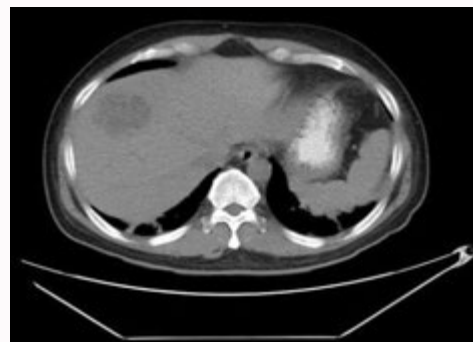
Chest CT scan: bilateral variable size lung nodules, some cavitating, some showing mixed solid and cystic densities and cluster of variable size nodules and fibrotic densities seen in the posterobasal segments of bilateral lower lobes and liver findings of Mild hepatomegaly with a cluster of multivesicular cysts. Primary consideration is Hydatid disease.
